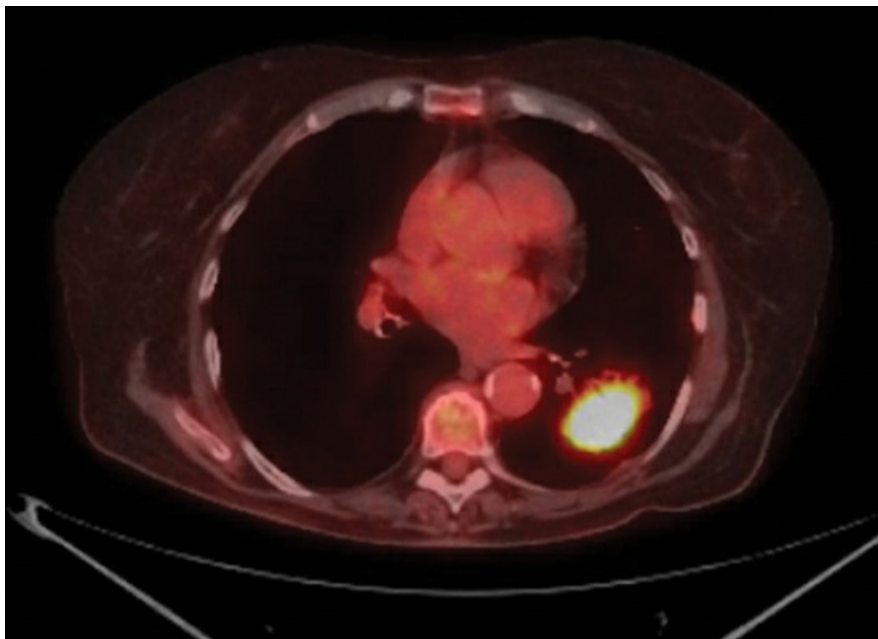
Combined positron emission tomography–computed tomography (PET-CT) scan showing uptake of 18-fluorodeoxyglucose in a left lower lobe adenocarcinoma of the lung.
